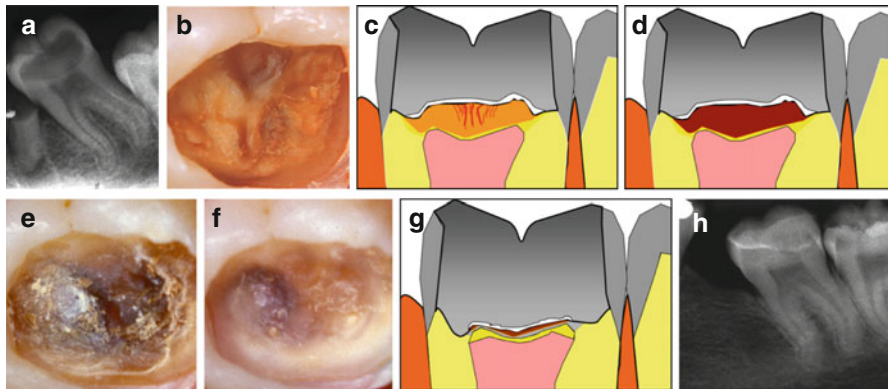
Principle demonstration of the stepwise excavation approach of a molar. (a) Radiographic feature of a secondary molar with deep caries. (b) Cariogenic surface plaque and undermined enamel removed visualizing the exposed carious dentin. (c) A sketch of the temporization of the retained active carious dentin after 1-step. (d) After the treatment interval retained carious dentin will become darker, harder, and drier. (e) The retained carious dentin shown after removal of the temporary restoration. (f) Complete excavation is carried out to optimize the cavity for final restoration, and has been facilitated due to decrease of caries activity. (g) A sketch of the permanent restoration is in place. (h) A 4-year follow-up with no apical pathology. However, complete arrest of caries activity has not been achieved; a new proximal lesion has progressed in the third molar
